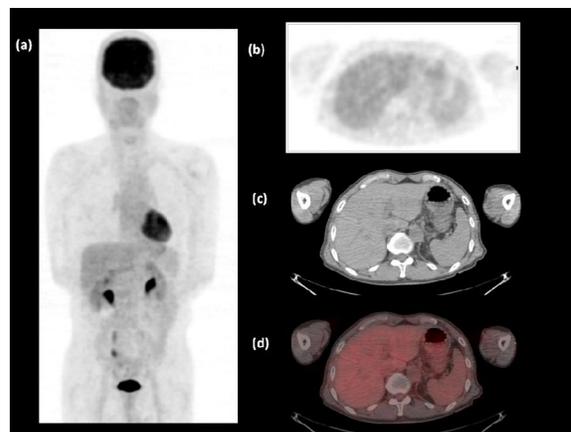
A 70-year-old male with a homogenous pattern on the  $^{18}\text{F}$ -FDG-PET/CT image of the liver. (a) PET volume image, (b) PET cross-section image, (c) CT images, and (d) fusion PET/CT image.
